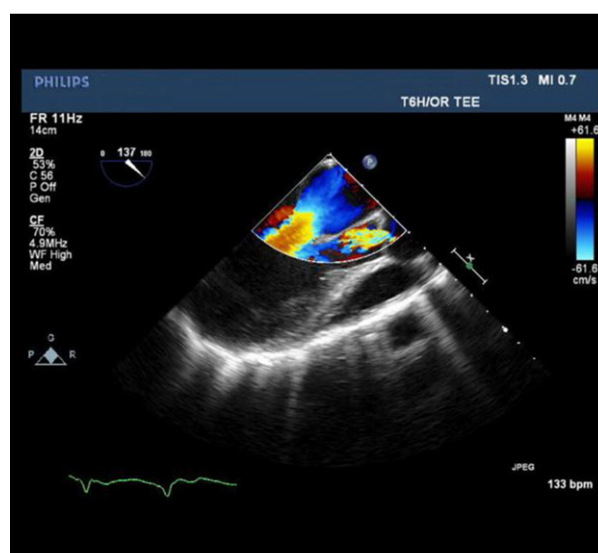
A transesophageal echocardiogram of the midesophageal aortic valve long-axis view showing severe aortic regurgitation with color-flow Doppler.
